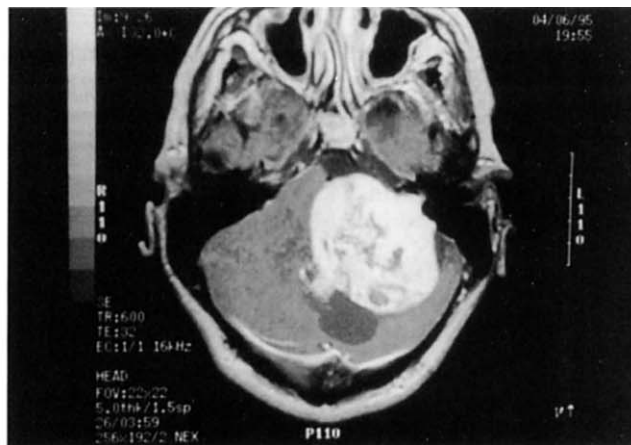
T-1 weighted, gadolinium-enhanced magnetic resonance image showing large unilateral vestibular schwannoma with life-threatening brainstem compression and hydrocephalus.
